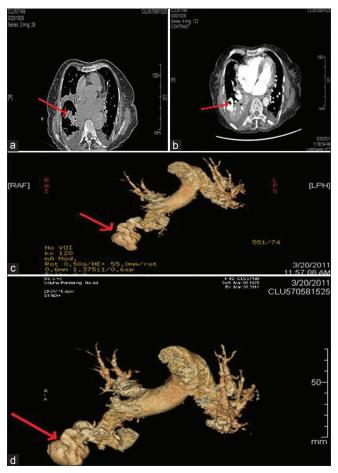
(a) Non-contrast CT chest showing a well-circumscribed serpiginous mass in the right lower lobe of the lung (b) Contrast CT chest showing contrast enhancement of the serpiginous mass (c) CT pulmonary angiogram showing large AV malformation arising from the right descending pulmonary artery, drained by an enlarged tributary of the pulmonary vein (d) CT pulmonary angiogram showing large AV malformation arising from the right descending pulmonary artery, drained by an enlarged tributary of the pulmonary artery, drained by an enlarged tributary of the pulmonary artery, drained by an enlarged tributary of the pulmonary vein
